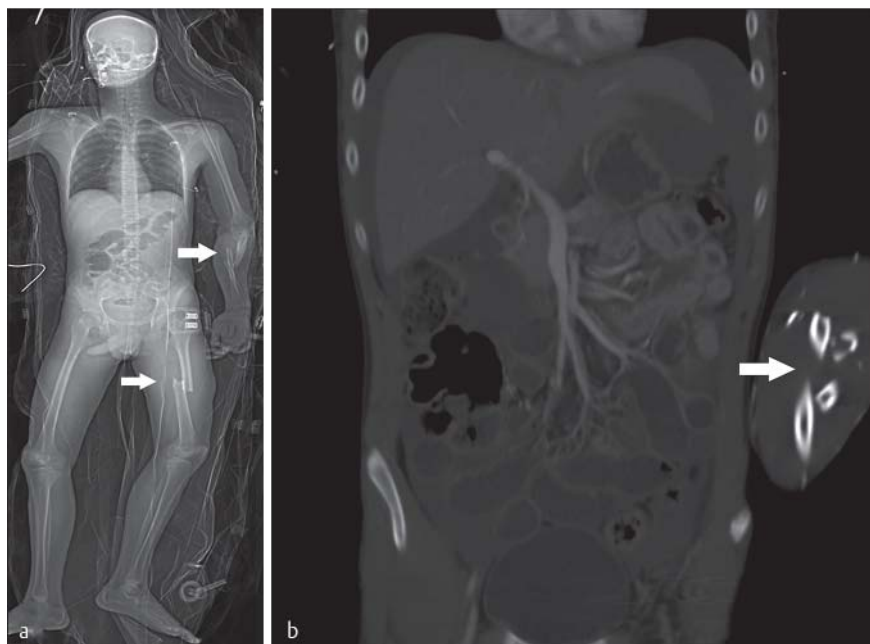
LS-scan of a 19-year-old man after a motor vehicle accident and resuscitation a. While the whole-body scan with LS covered the dislocated fracture of the left thigh as well as the dislocated fracture of the left forearm (indicated by arrows) a, the CT scan only covered the left forearm fracture (indicated by arrow) (b; CT, coronal reformation).
